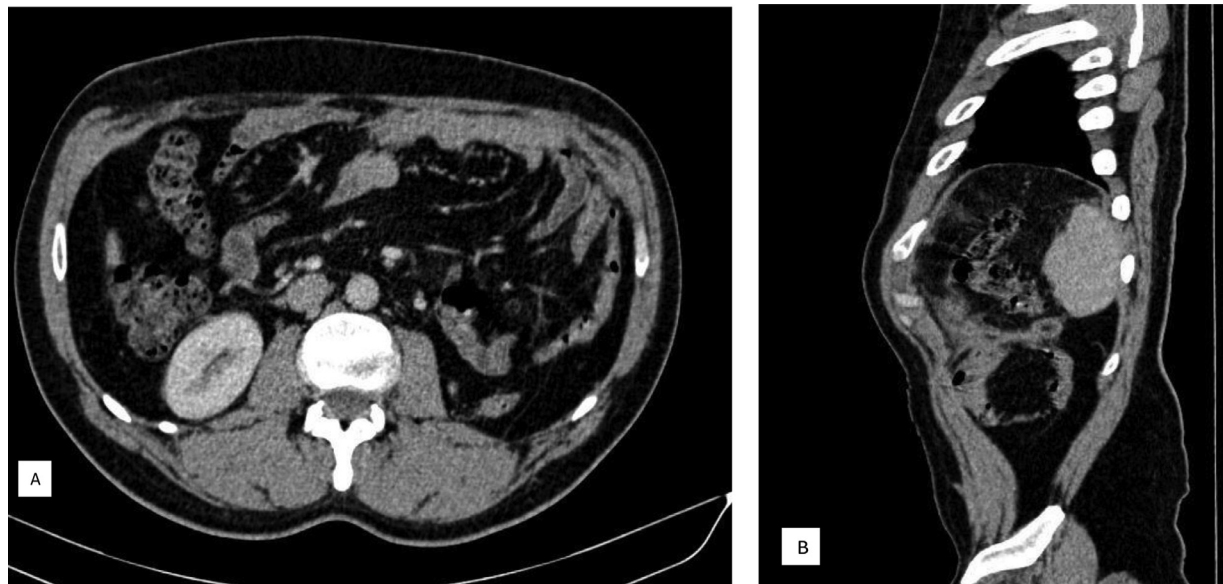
Contrast-enhanced abdominopelvic computed tomography control (A: axial, B: sagittal), showing the total regression of the omental infarction.
